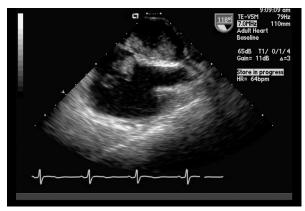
A transesophageal echocardiogram (mid-esophageal position, long-axis view) shows a left atrial myxoma prolapsing through the mitral valve.
